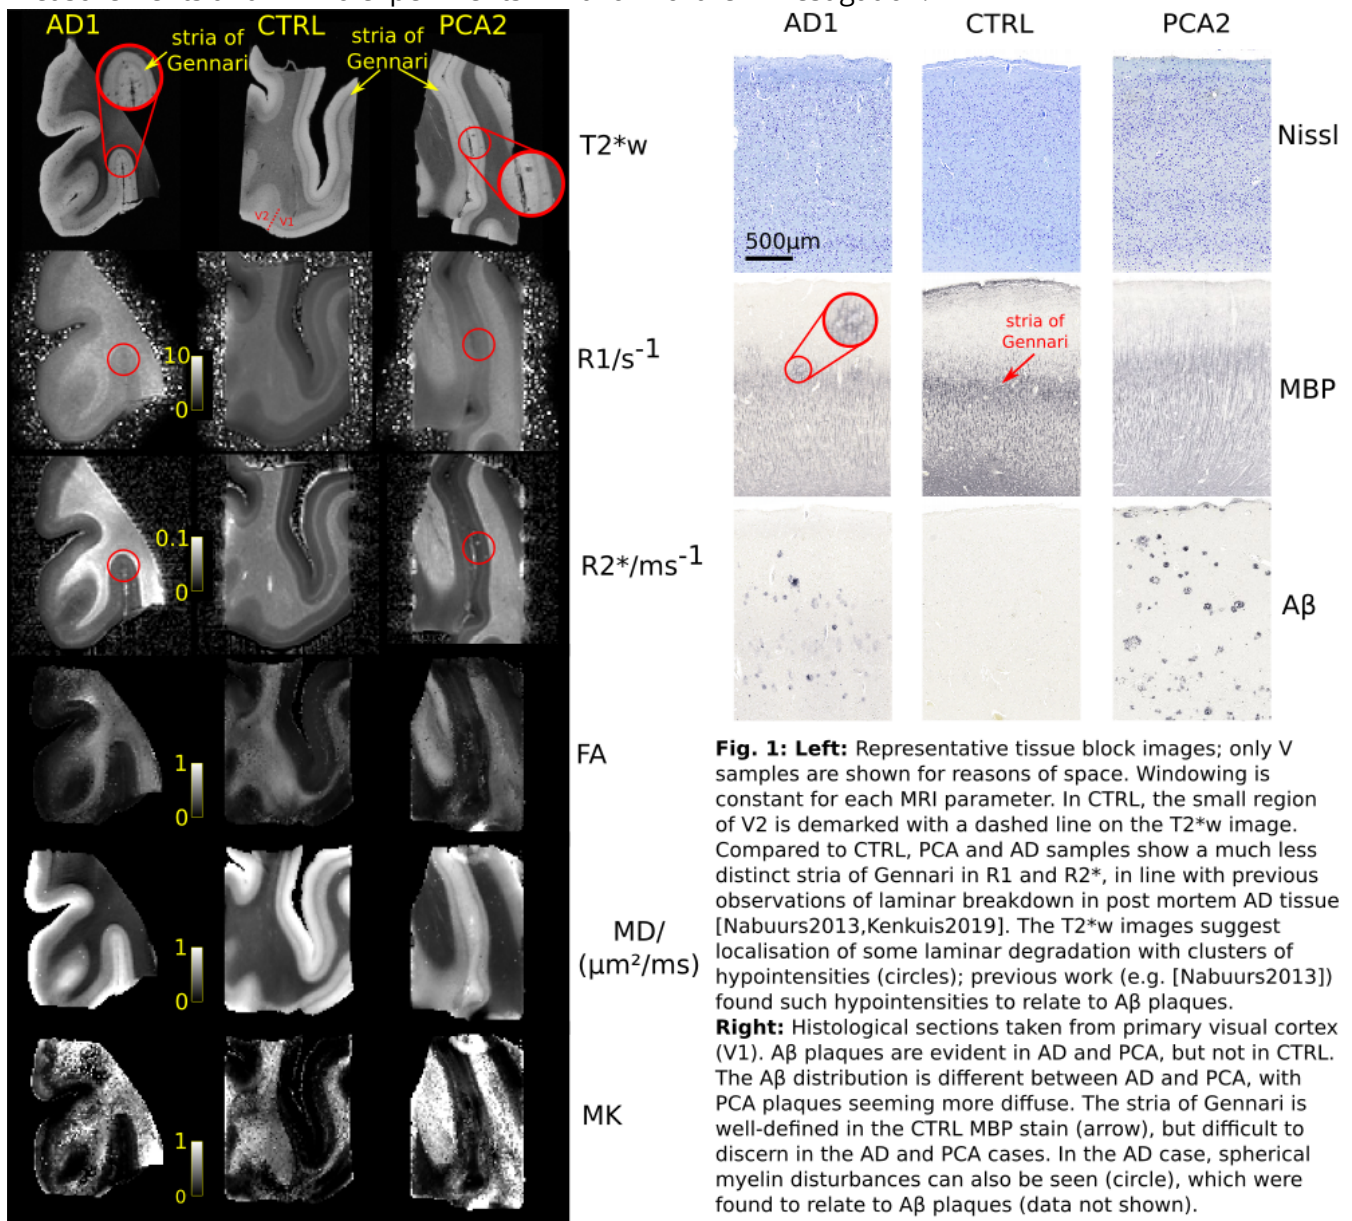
Left: Representative tissue block images; only V samples are shown for reasons of space. Windowing is constant for each MRI parameter. In CTRL, the small region of V2 is demarked with a dashed line on the T2*w image. Compared to CTRL, PCA and AD samples show a much less distinct stria of Gennari in R1 and R2*, in line with previous observations of laminar breakdown in post mortem AD tissue [Nabuurs2013,Kenkuis2019]. The T2*w images suggest localisation of some laminar degradation with clusters of hypointensities (circles); previous work (e.g. [Nabuurs2013]) found such hypointensities to relate to $A\beta$ plaques.
